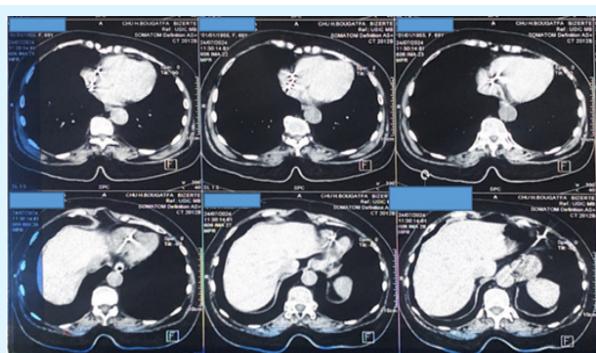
CT scan with right ventricular perforation by the pacing lead
